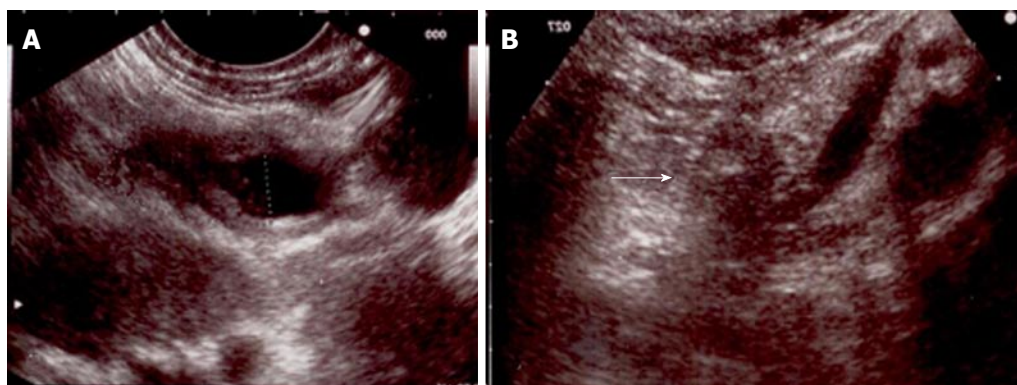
Endoscopic ultrasound appearances before (A) and after (B) treatment (white arrow).
